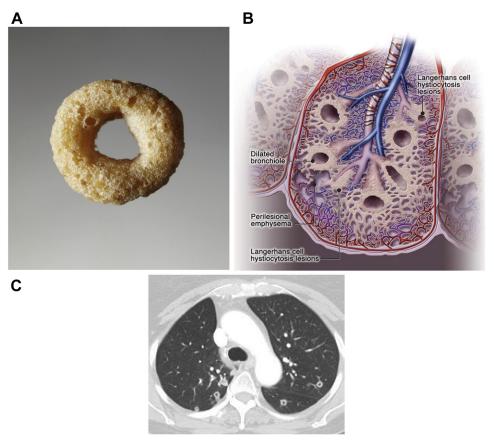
A, Photograph of a Cheerios breakfast cereal. (Image courtesy of Evan Dion, www.evandion.com.) B, Artist's rendition of the pulmonary Langerhans cell histiocytosis lesions with proliferation of Langerhans cells around dilated bronchioles, showing the Cheerios sign. (Reprinted with permission from Chou et al.¹⁵ © Wolters Kluwer Health, Inc.) C, Cheerios sign seen on chest CT scan in a patient with biopsy proven pulmonary adenocarcinoma. (Image courtesy of Dr Subha Ghosh.)
